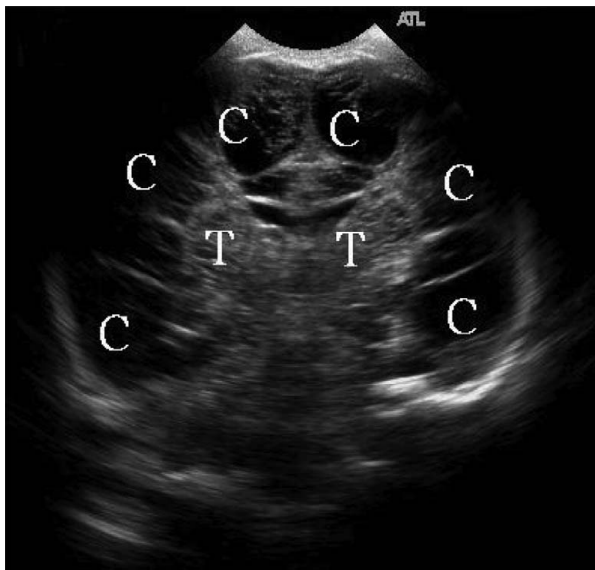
Ultrasound of the brain of twin B at 5 days old (coronal view). Diffuse multiple cystic formations over cortex are seen. C = cystic formations; T = thalamus.
